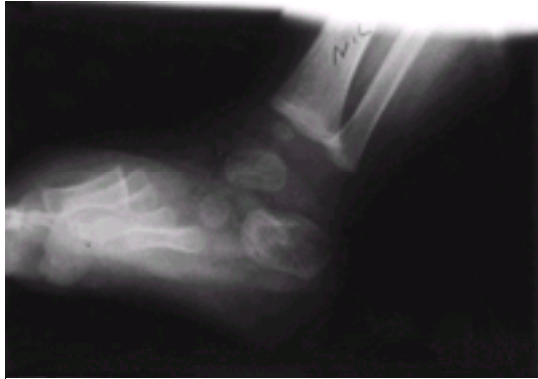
This lateral radiograph shows a clubfoot treated with Achilles tendon lengthening, which went on to recur. In this postoperative film, the long axis of the talus is still almost parallel to that of the calcaneus (the axes are not drawn in), which indicates incomplete correction. In a corrected foot, and in a normal foot, the lateral talocalcaneal angle should be 30 to 50 degrees.
